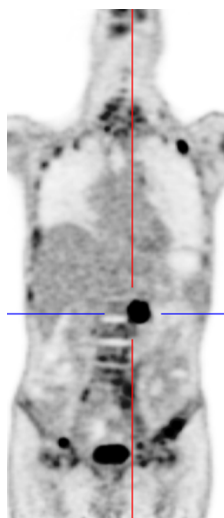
(P17); 18-year-old-male with NIDDM and abdominal paraganglioma (hairline marker) (SUVmax: 15.79)
